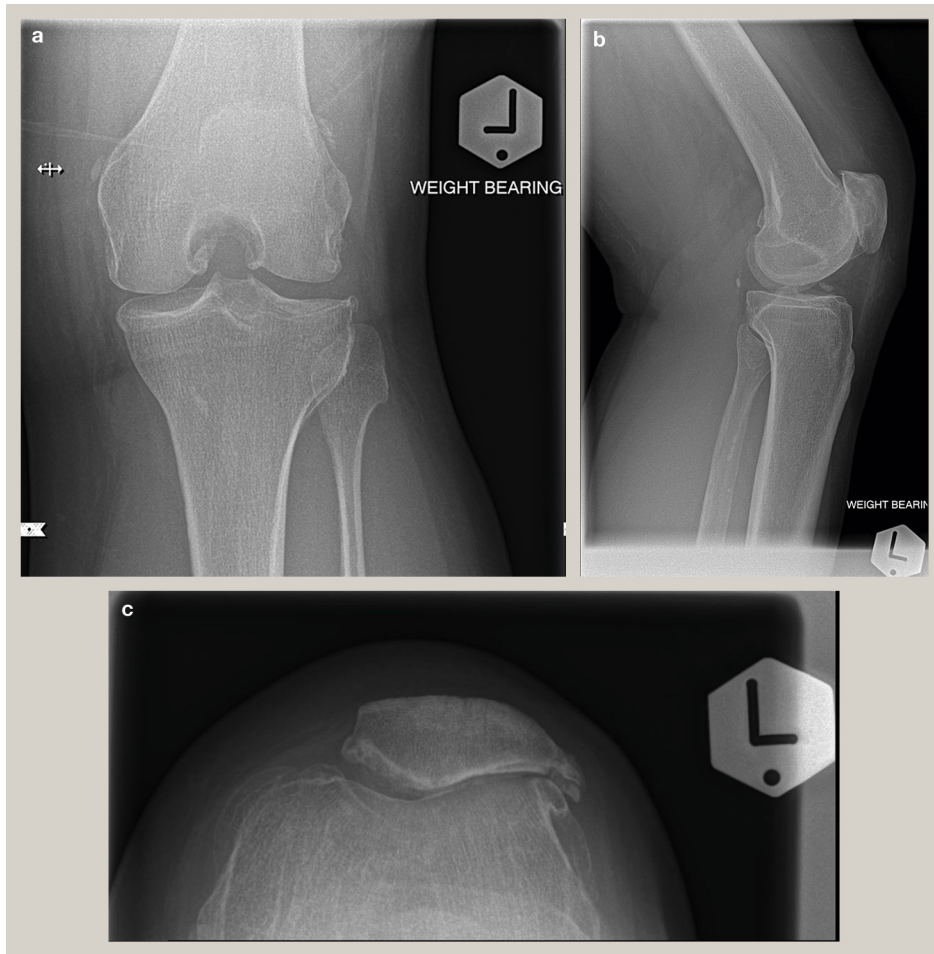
(a) Weight-bearing Rosenberg, (b) Lateral and (c) Merchant radiographs, demonstrating lateral facet patellofemoral osteoarthritis with a well-preserved tibiofemoral articulation.
